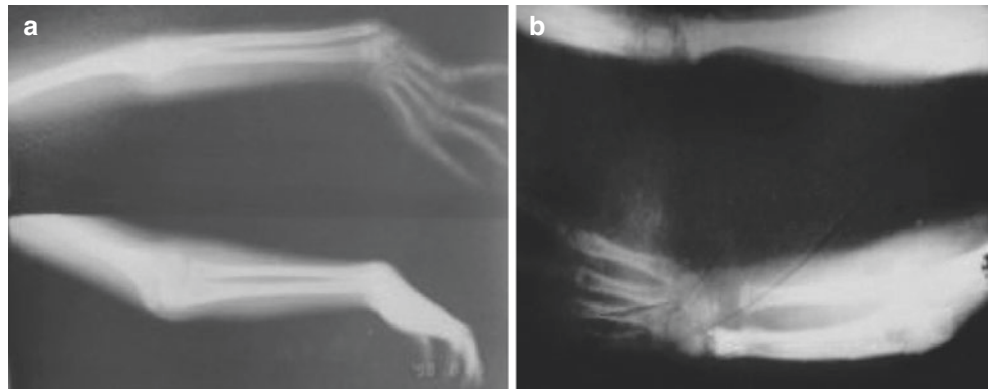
X-ray findings of type II radial club hand
